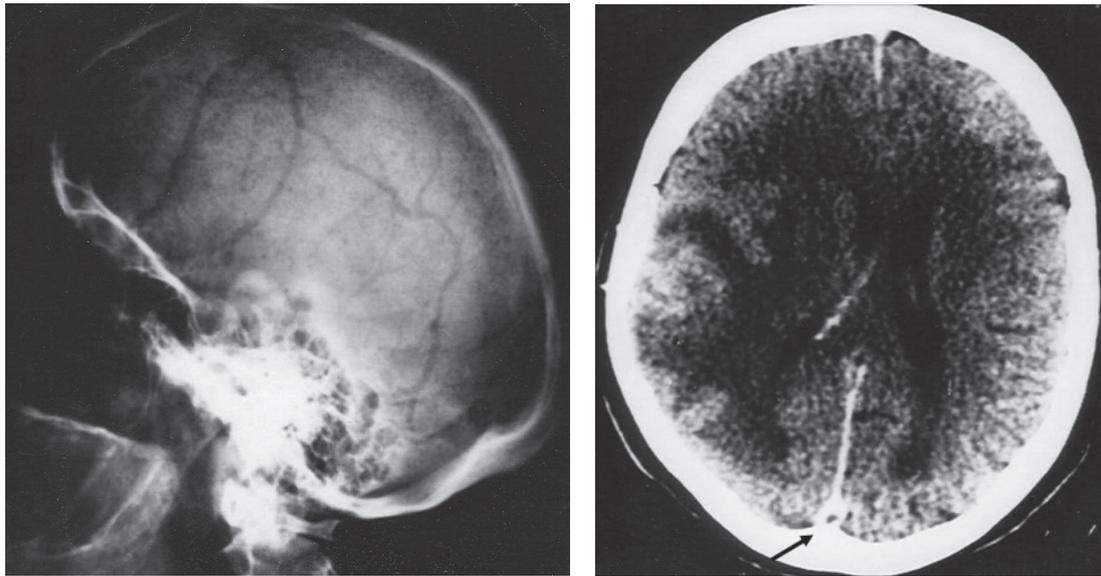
(A) X-Ray skull-lateral view showing multiple "punched out" bony lesions. (B) Contrast enhanced cranial computerized tomography, axial section, showing "empty delta sign" (arrow) in superior sagittal sinus.
